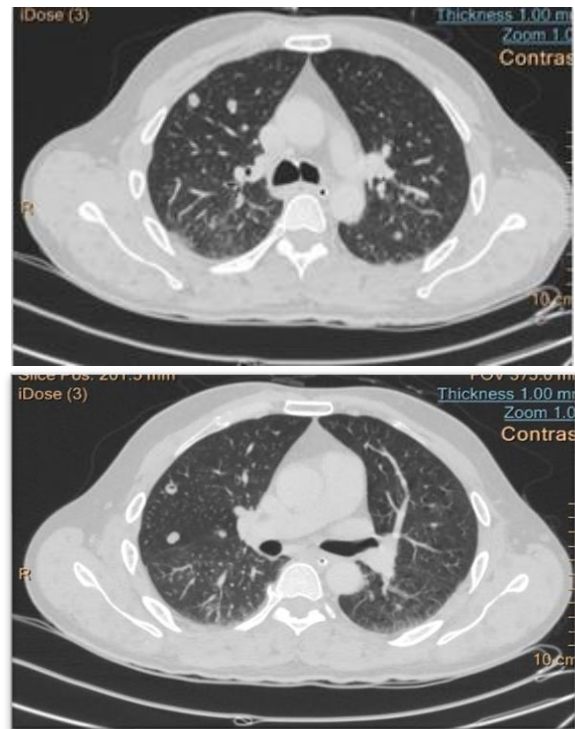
CT chest showing bilateral multiple hyperintense round opacities in lung parenchyma without any ground glass opacities and consolidation, likely to be infective in origin along with hypoechoic multiple lesions in paravertebral and adjacent muscles. Multiple cysticerci-tubercular origin.
